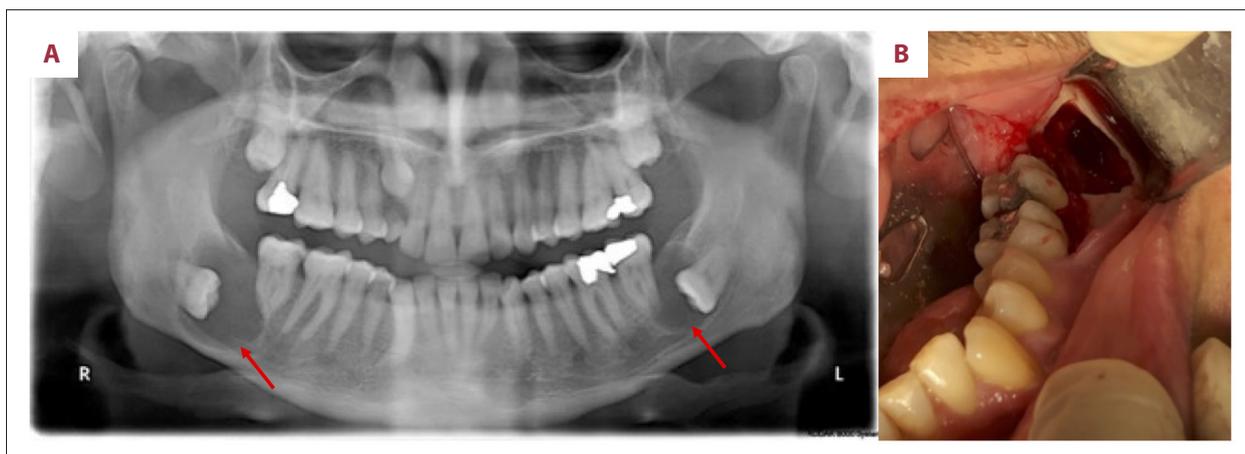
Bilateral mandibular dentigerous cysts in a 44-year-old man. (A) Panoramic radiograph showing bilateral radiolucent lesions surrounding the crowns of impacted mandibular third molars (red arrows). (B) Photograph of the cavity after removal of the left-sided cyst and the impacted tooth.
